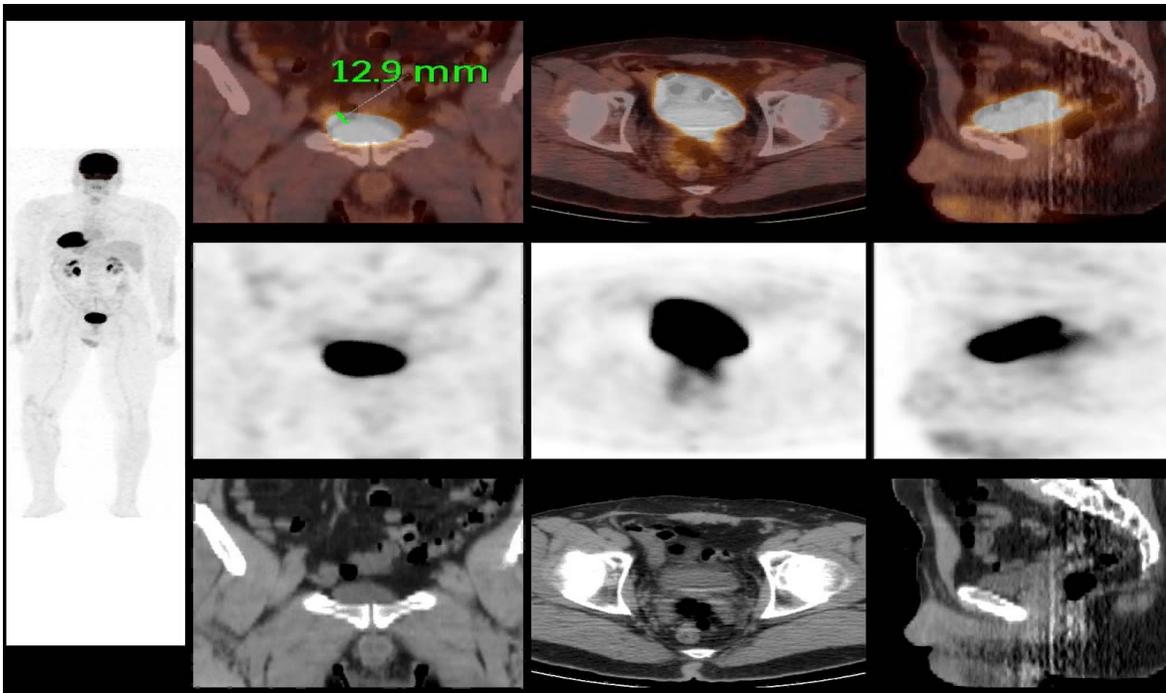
54 year old male with restless leg syndrome. This is an example of non-preventable misregistration of 12.9 mm in the bladder, due to variable filling time interval between the CT Transmission and PET Emission scans.
